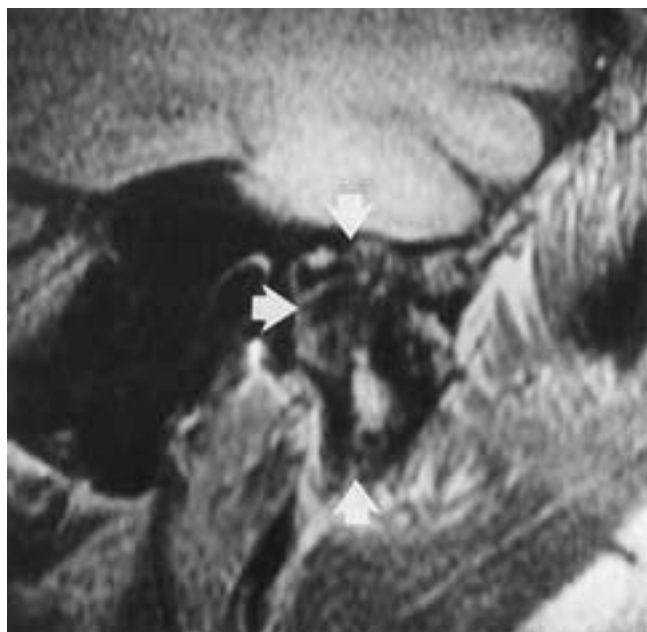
Intraarticular adhesions following diskectomy. Sagittal MR image 2 years after diskectomy. There is an irregular area of low signal intensity in the entire joint region (*arrows*). This is indicative of extensive fibrous adhesions.
